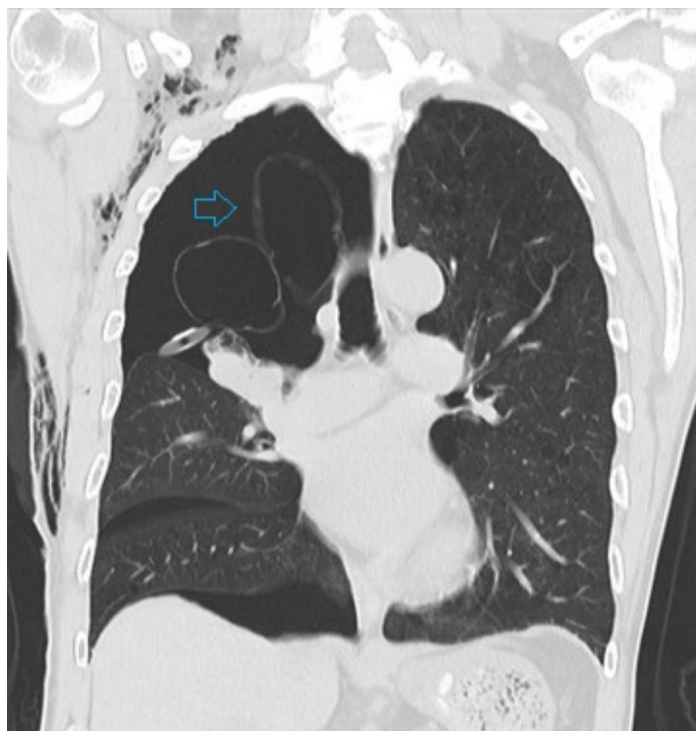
CT image showing a large pneumothorax with underlying bullae on the right side (Arrow) with emphysematous changes on the left side
